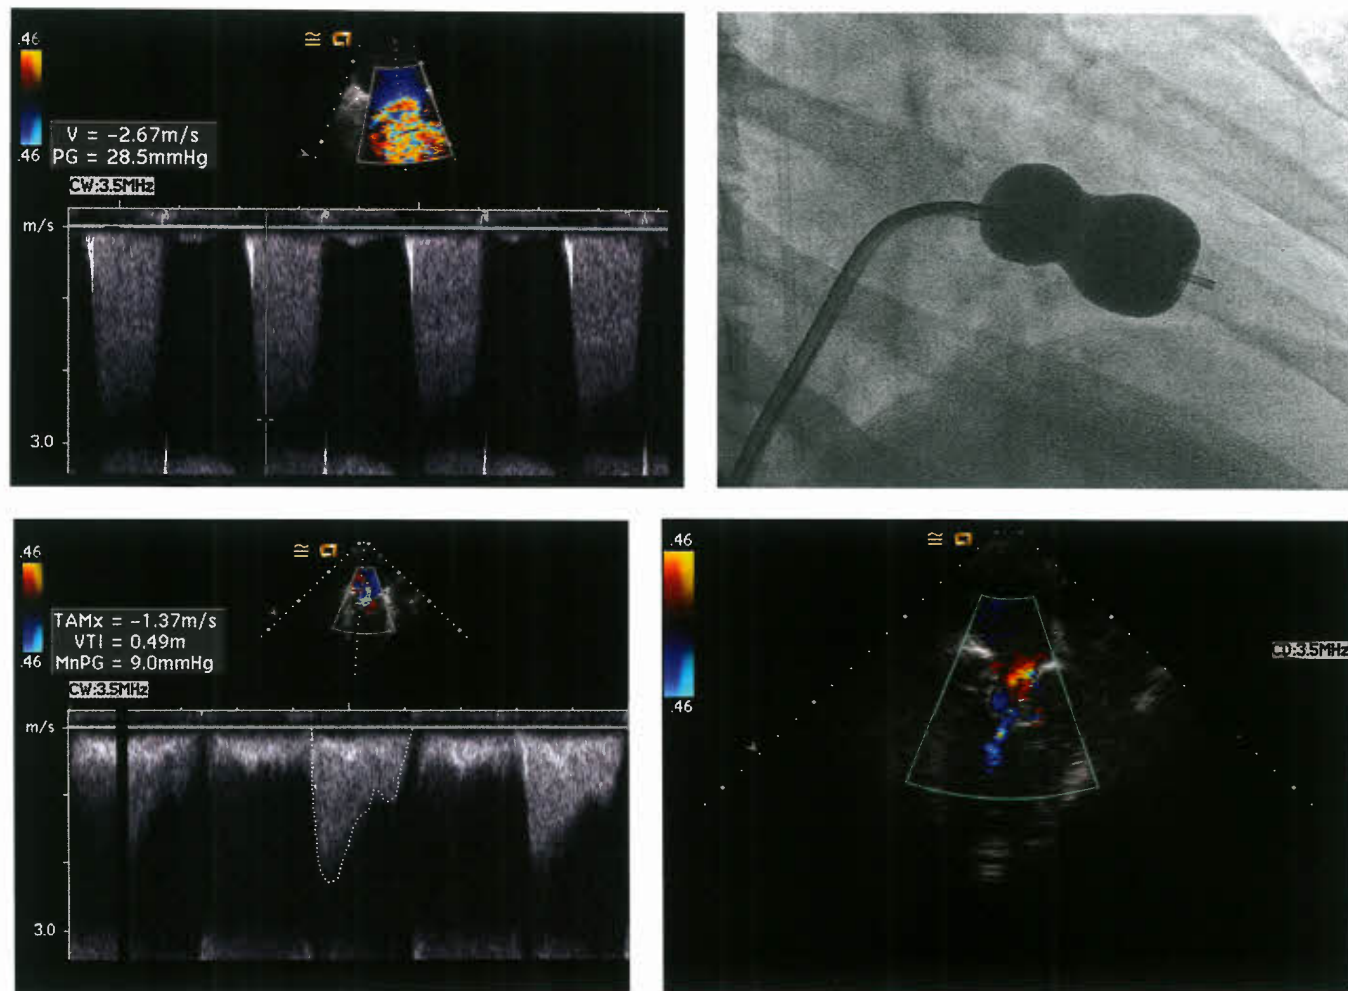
Mitral “Inoue” balloon valvuloplasty. A 38-year-old woman with rheumatic MV stenosis. Inoue BMVP reduced the mean gradient from 28 to 9 mm Hg with mitral regurgitation increasing from trivial to mild. Top left: 28 mm Hg mean Doppler gradient across MV prior to balloon valvuloplasty. Bottom left: 9 mm Hg mean Doppler gradient across MV postballoon valvuloplasty. Top right: Inoue balloon inflated across MV. Bottom right: Mild mitral insufficiency by color Doppler after balloon valvuloplasty.
